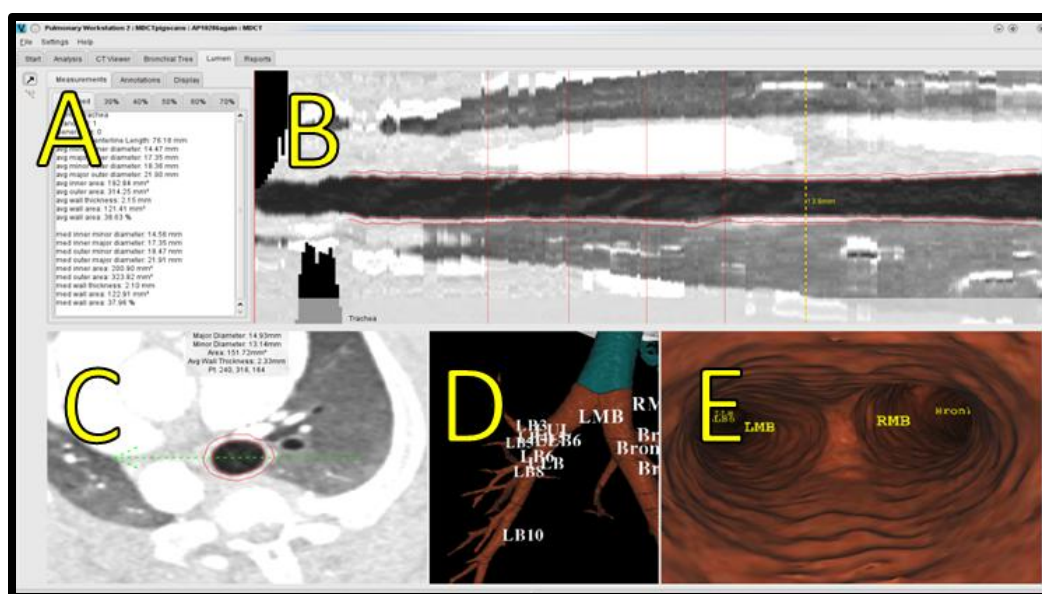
The airway measurement interface of PW2. Region A shows the measurements. Region B shows the highlighted airway artificially straightened. Region C shows a CT cross-section of the segment under measurement. The red ellipses surrounding the central airway mark the border PW2 has identified as the inner and outer airway wall. Measurements are based upon these ellipses. Region D shows the airway tree volume rendering and Region E the virtual bronchoscopy.
